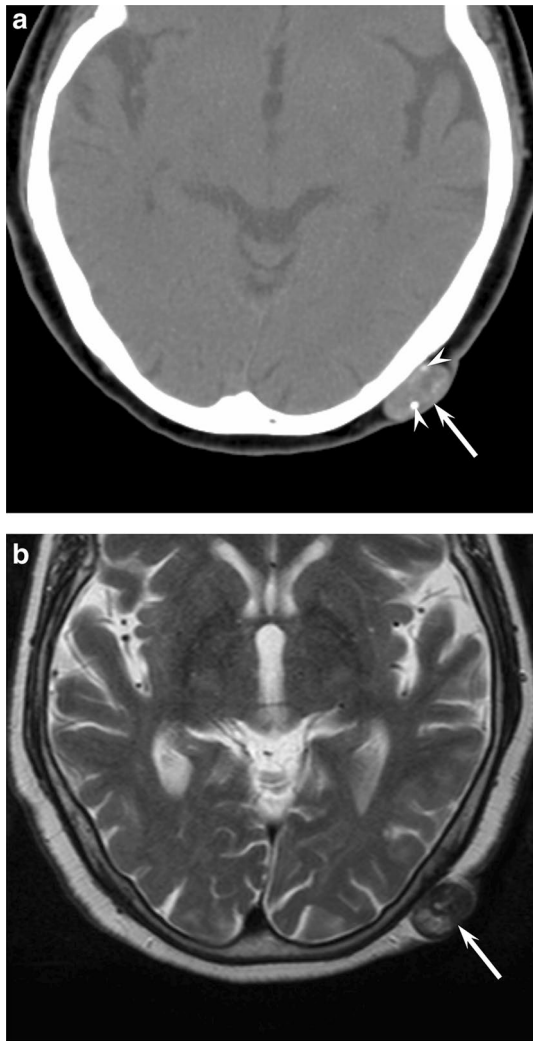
A 75-year-old woman with trichilemmal cyst. a. Unenhanced CT image shows a well-demarcated subcutaneous lesion (arrow) with calcification (arrow heads). b. T2-weighted image shows heterogeneously low to high signal intensity (arrow)
